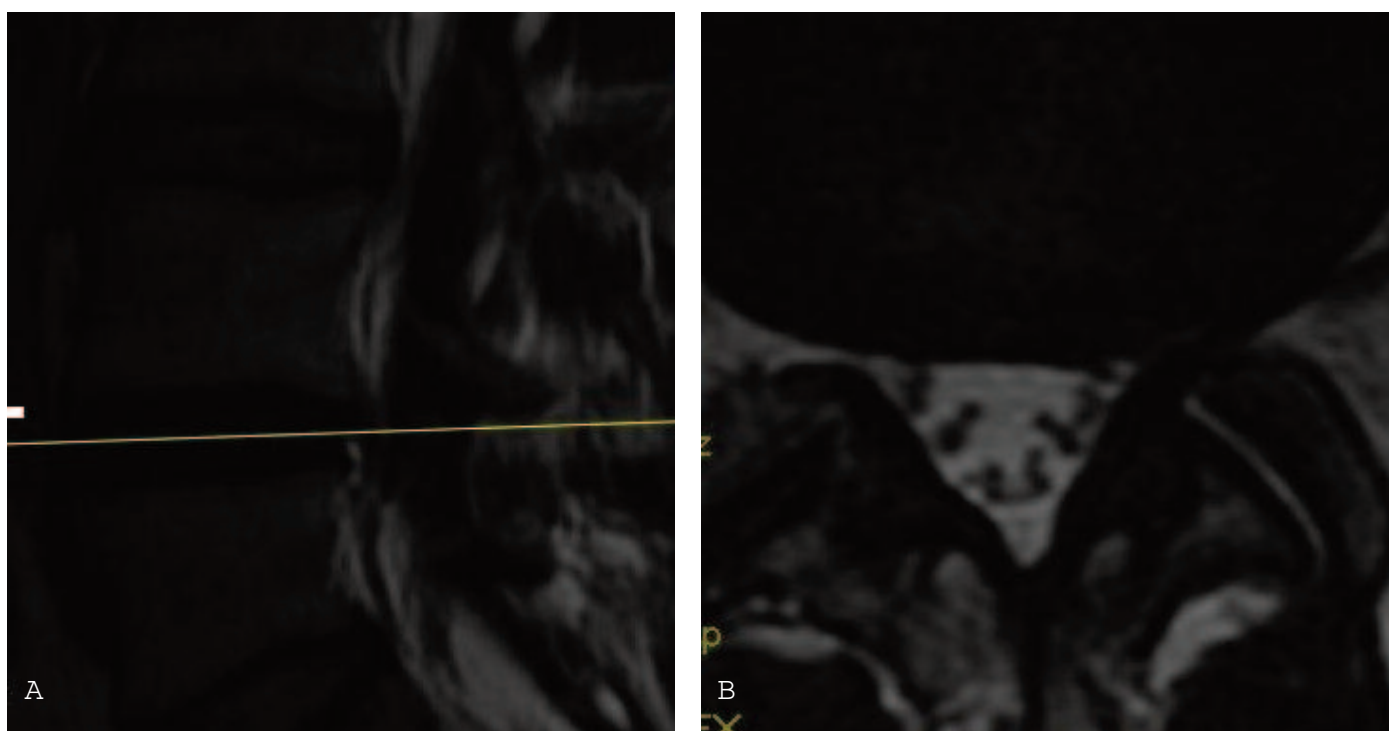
Mild foraminal protrusion was determined at the L4-5 level on MRI (a and b).
